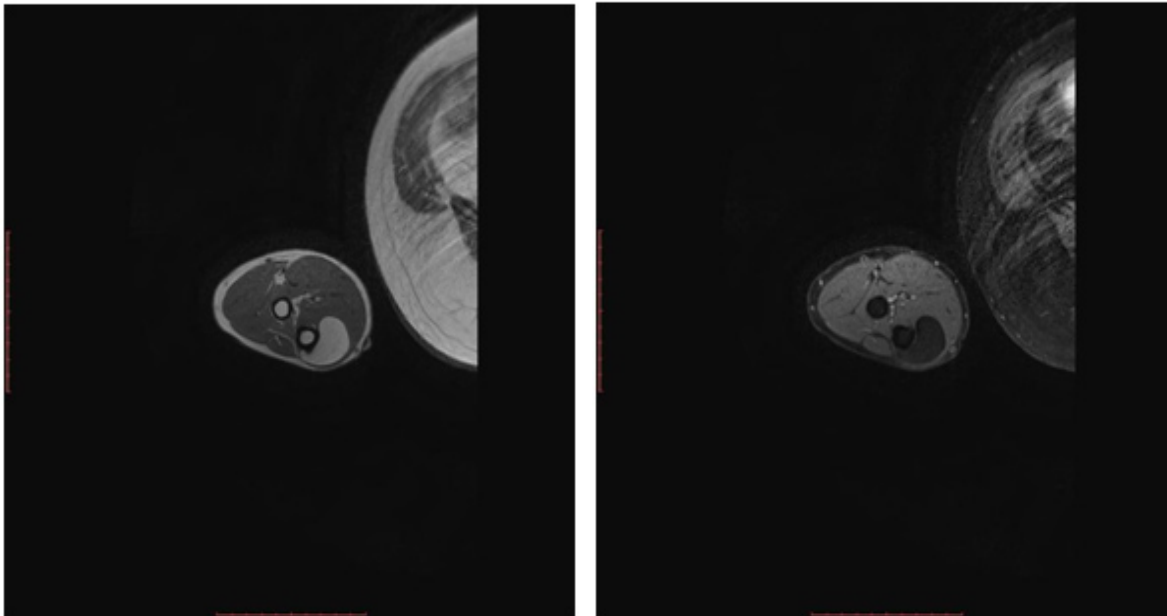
MRI axial (a) T1W and (b) T1W post contrast images with fat suppression shows complete suppression of internal signal intensity without any signal heterogeneity or post contrast enhancement. Focal cortical thickening is also evident.
